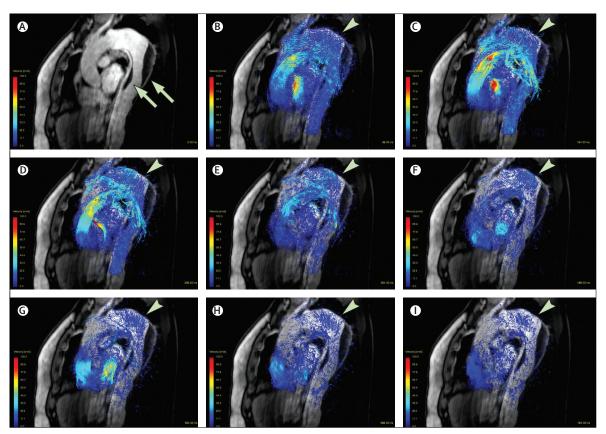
Morphological and 4D functional MRI
